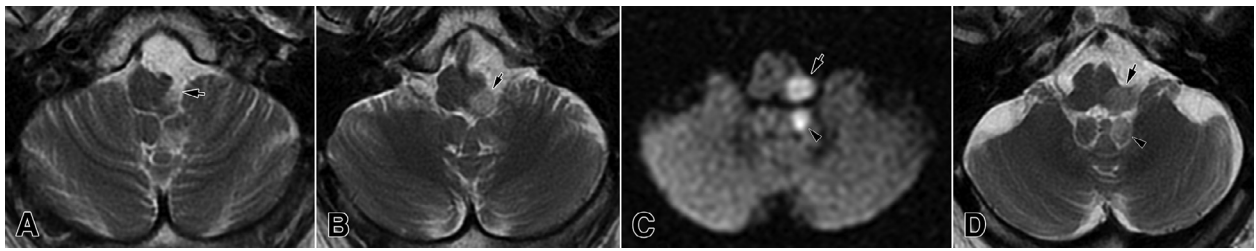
A large left laterodorsal infarction (arrows) of the middle and upper medulla in the PICA territory. It is presented in the axial T2-weighted (A, B and D) and DWI (C) images. Note involvement of the cochlear nuclei (D) and a small ipsilateral paravermian region (arrowheads in C and D).
